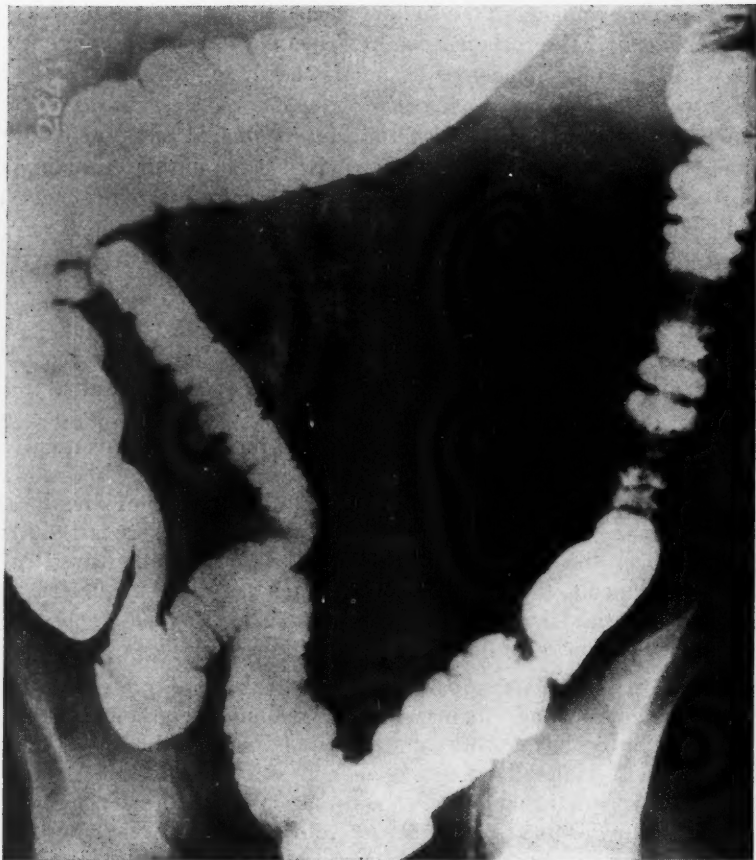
Adenomatous polyposis of the rectum and sigmoid colon with early carcinomatous change in the rectal polypi. The usual roentgenogram taken when the colon is distended with barium suspension shows no abnormality in sigmoid colon.
